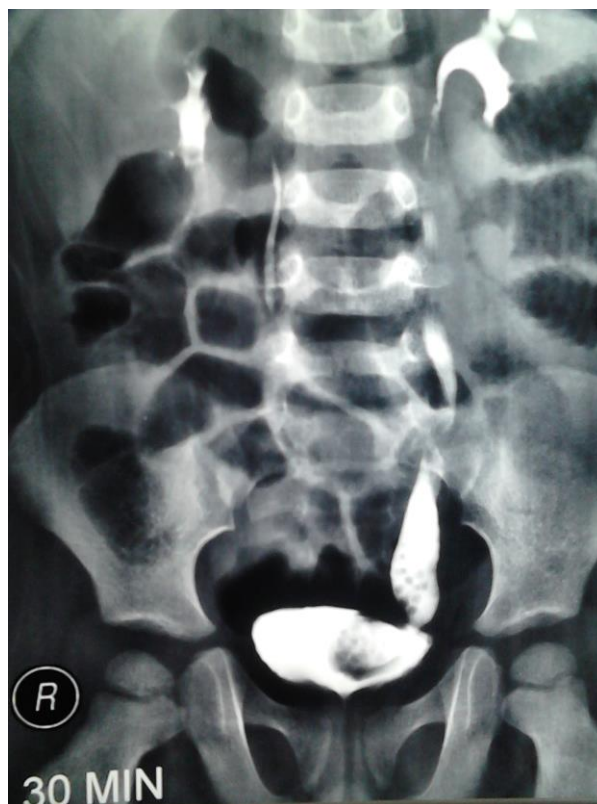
X-Ray Ivp Showing Ureterocele With Stone
